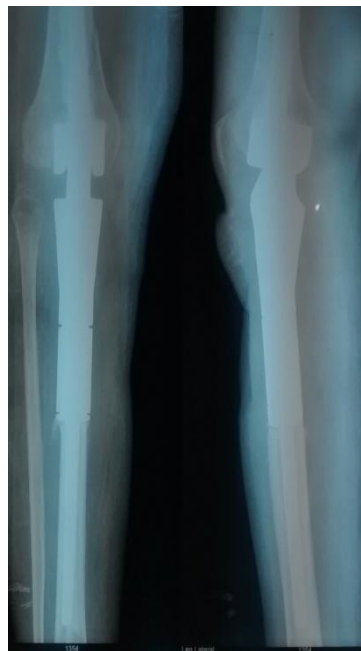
radiograph after tumour excision and stabilisation by K - nail
